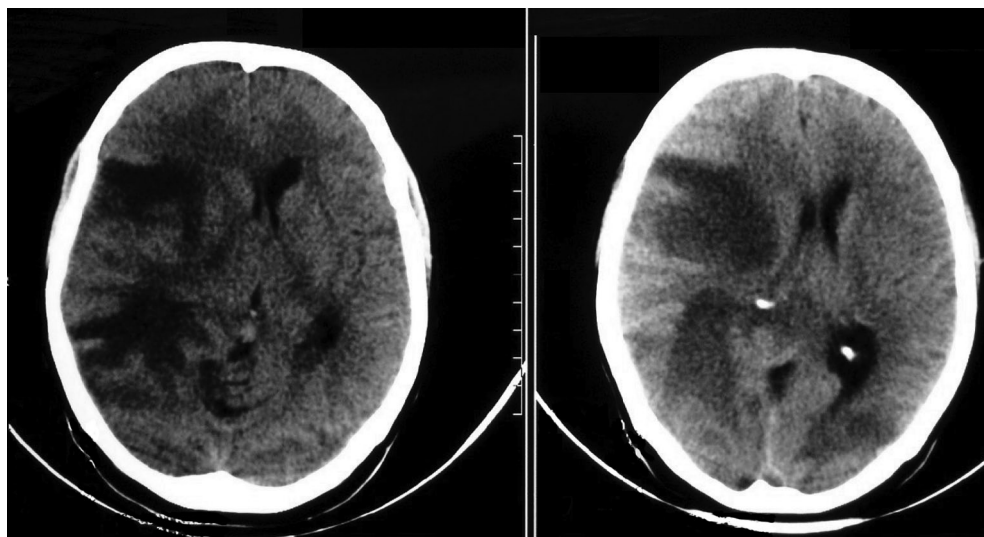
Head computed tomography showing a hypodensity area in the right frontal-parietal region with mass effect and midline deviation.
